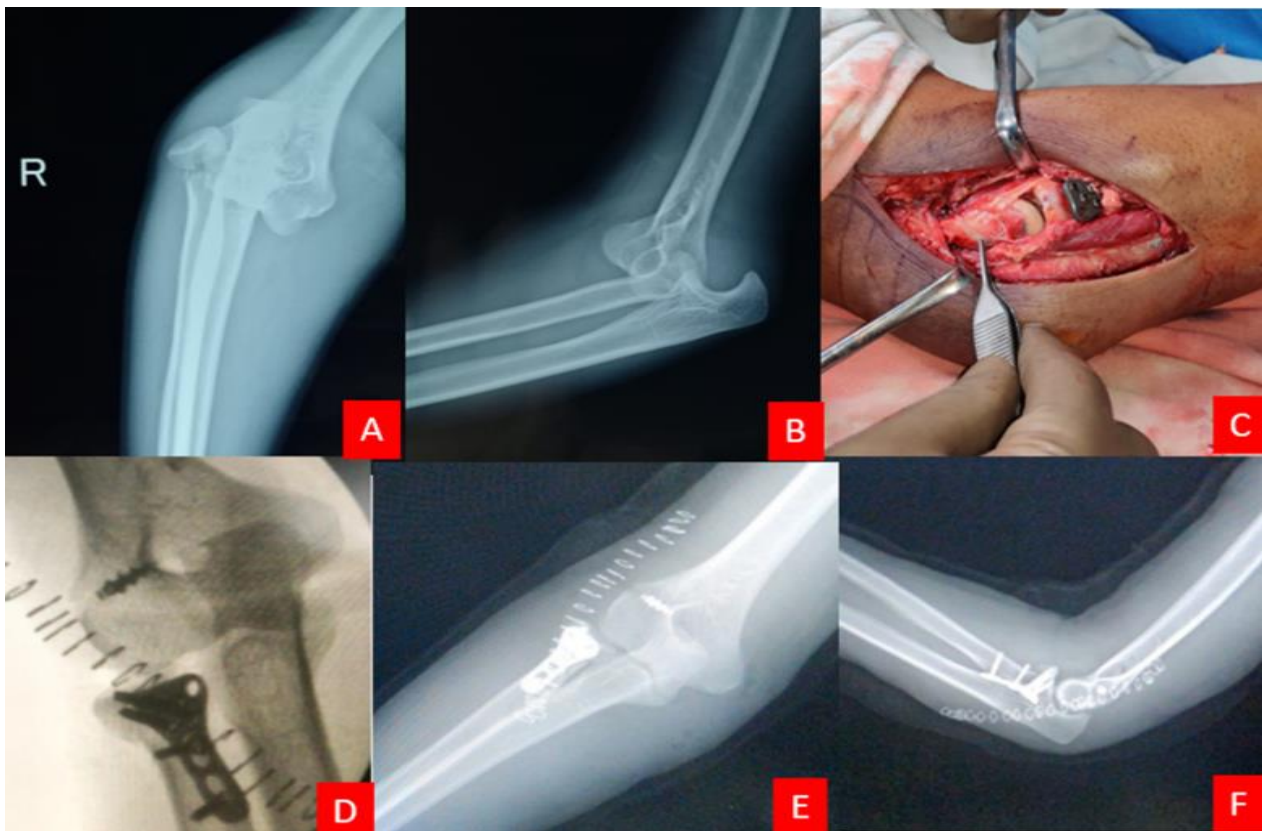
A & B) Pre-operative X-rays showing Mason's type IV radial head fracture with elbow dislocation. C) Intra-operative image showing the exposed lateral epicondyle with complete avulsion of lateral collateral ligament. D) Intra-operative IITV image confirming the position of suture anchor. E & F) Post-operative X-rays showing appropriate implant position and reduction of fracture-dislocation
